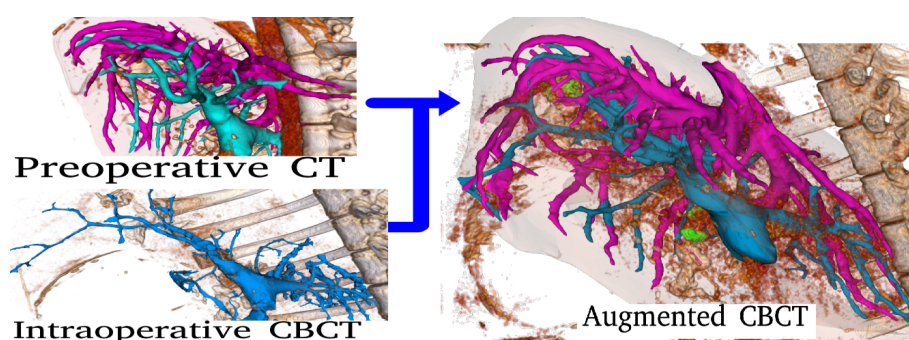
In the top left the preoperative CT image with complete portal and hepatic vessels clearly visible. In the bottom left the intraoperative deform, noisy CBCT image with partial only partial portal vessels visible. In the right the augmented CBCT view with the complete vessels added form preoperative image.
